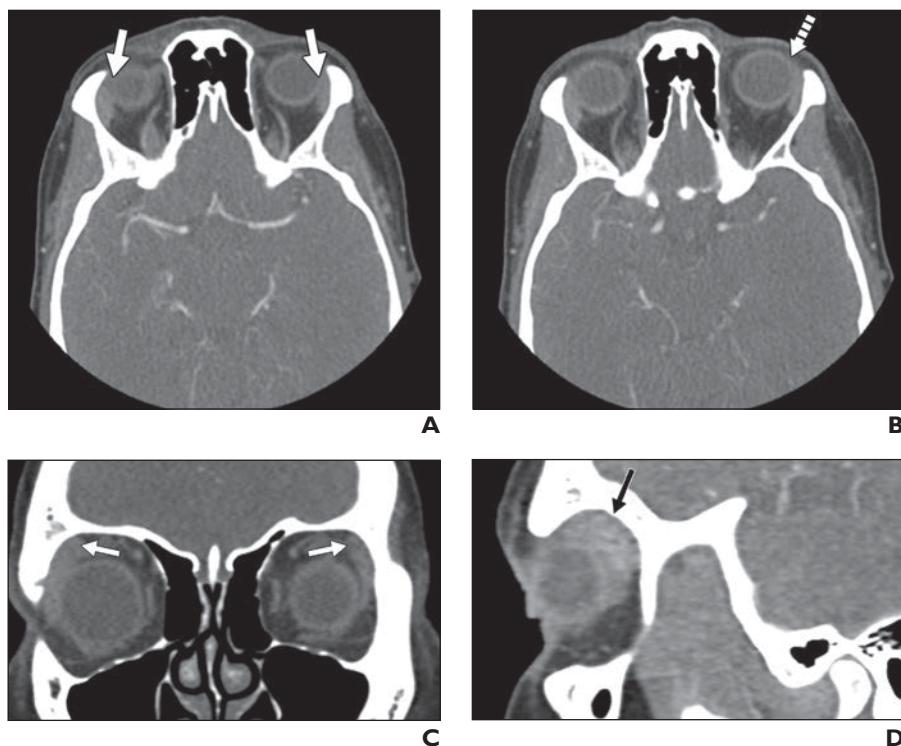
Normal CT of lacrimal glands.
